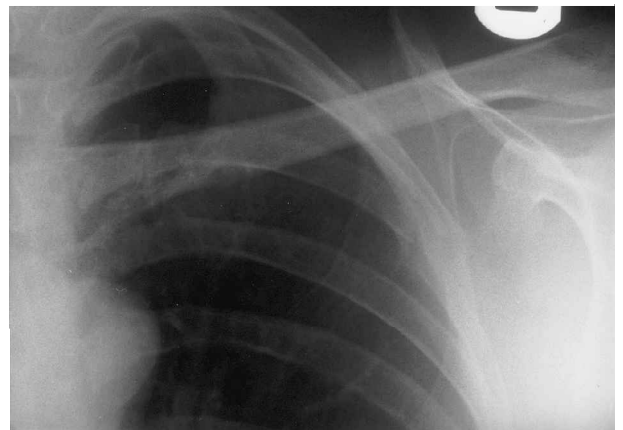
Radiograph of ribs demonstrating destructive osteolytic lesions affecting ribs 3 and 4.
